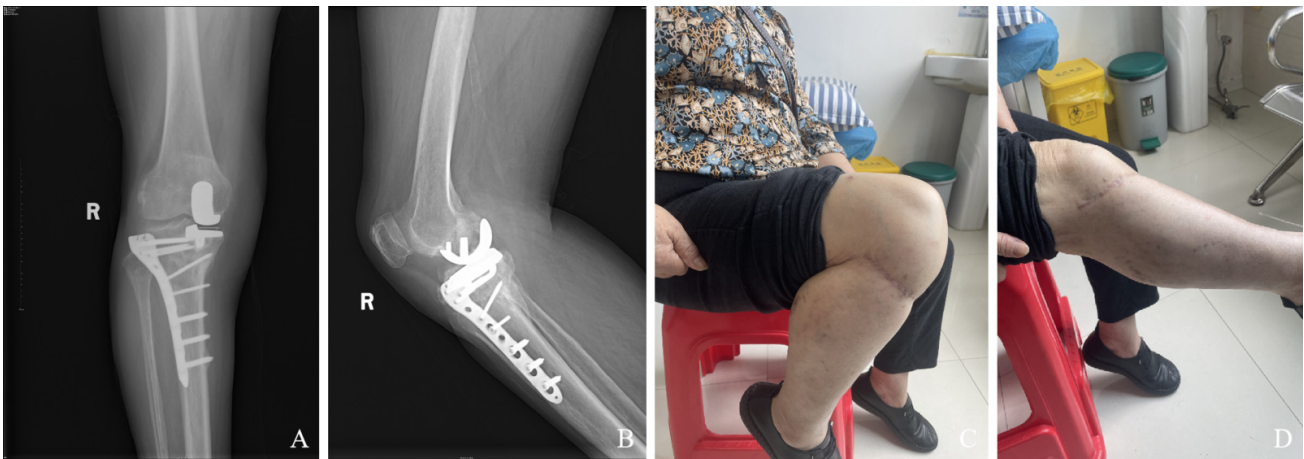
(A) Anteroposterior radiograph of the knee joint 1 year after internal fixation surgery; (B) Lateral radiograph of the knee joint 1 year after internal fixation surgery; (C) Flexion function of the knee joint 1 year after internal fixation surgery; (D) Extension function of the knee joint 1 year after internal fixation surgery.
